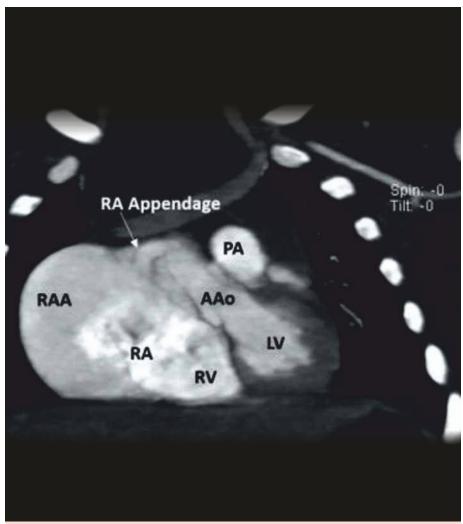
Pre-operative CT scan showing giant right atrial aneurysm (RAA)
